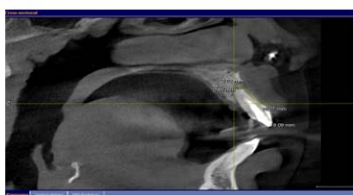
Pre-Op Cross Sectional CBCT
